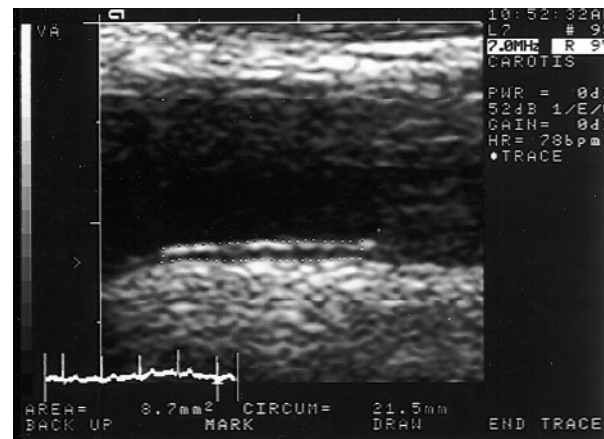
Ultrasonographic image of measurement of intima-media thickness in the distal portion of the common carotid artery.
